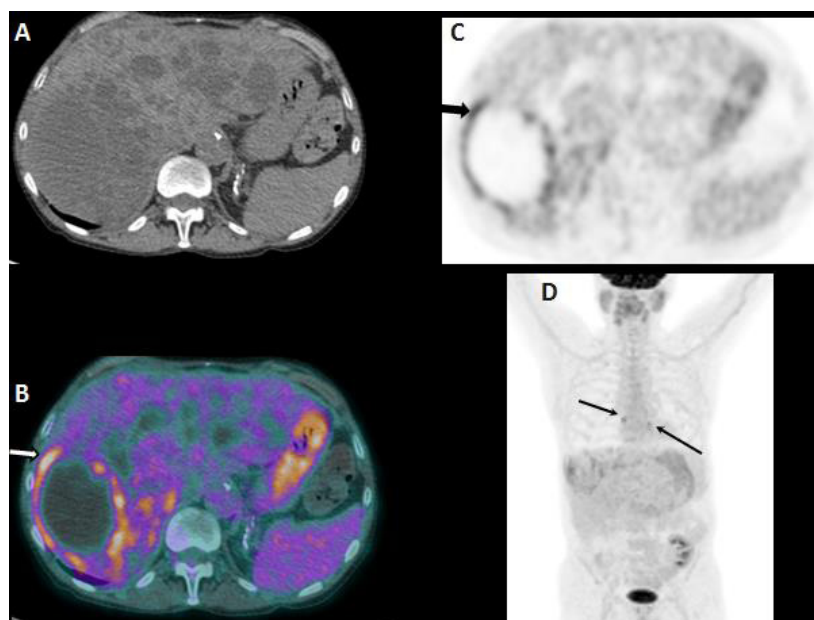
A–D. Axial CT (A), axial PET (B) and axial PET/CT (C) shows an increased FDG uptake in the liver between segment VI and VII corresponding to the wall of a big hepatic cyst. MIP (D) shows some mediastinal nodes FDG avid (thin arrows)
